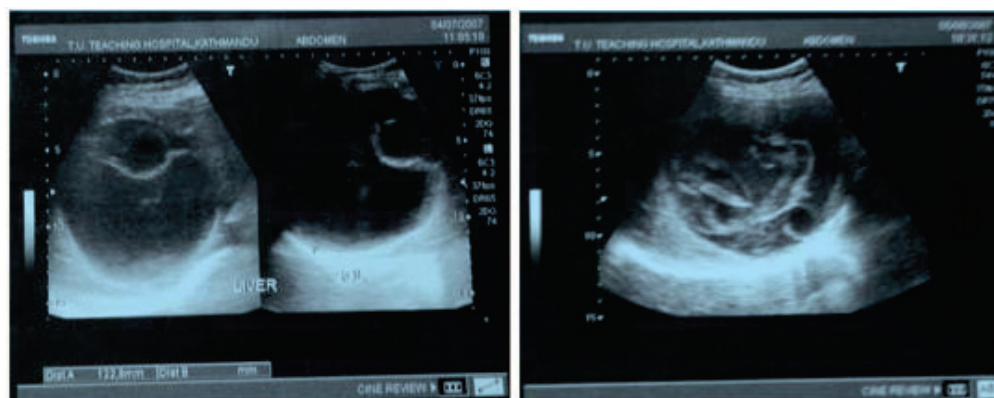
Ultrasonographic images showing Pre (04/07/2007) & post PAIR (05/08/2007, 1 month) hepatic hydatid cyst
